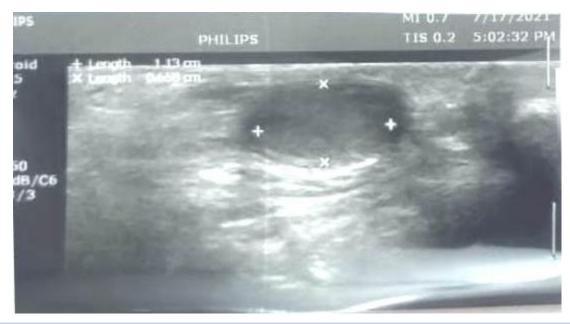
An ultrasound was performed and showed normal left testis in the scrotum
